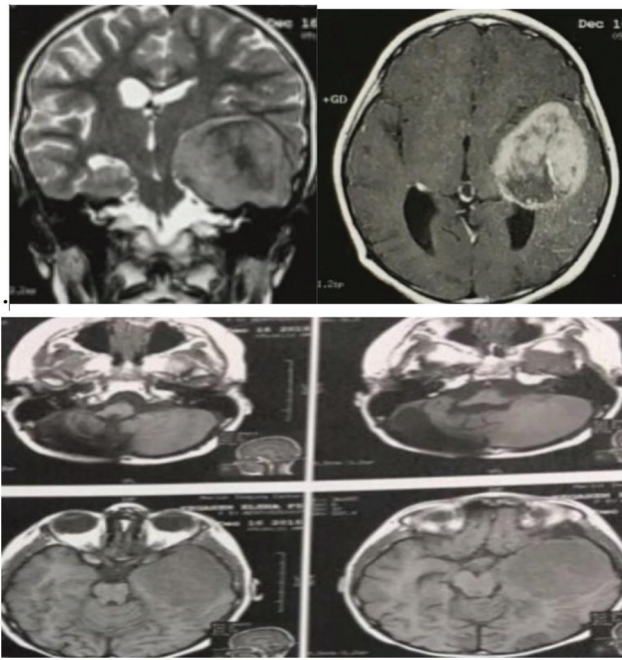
Brain MRI showing postoperative changes and cavity within the right cerebellar hemisphere, as well as a new T1 low, T2 high signal intensity intracranial enhancing mass lesion within the left temporal lobe measuring $\sim 68 \times 58 \times 46$ mm.
